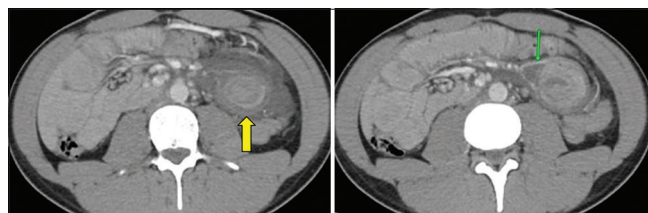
Multidetector computed tomography-enteroclysis in a 25-year-old male patient who had a known case of Henoch scanline purpura on treatment with recurrence presenting with complaints of intermittent abdominal pain, maroon-colored stools for 2 weeks, and rashes involving both lower limbs showed mural stratification and bowel wall edema with surrounding free fluid and prominent vascularity in the jejunum. These features suggest angioedema of the jejunum due to vasculitis
